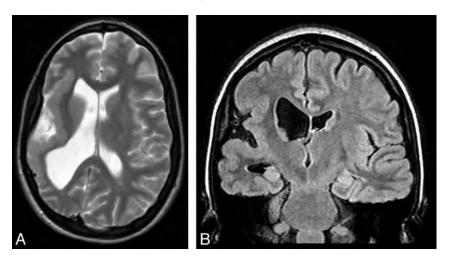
Coronal FLAIR and axial T2 MR imaging scans of a 19-year-old woman with epilepsy with polymicrogyria in the right insula and postcentral gyrus.
